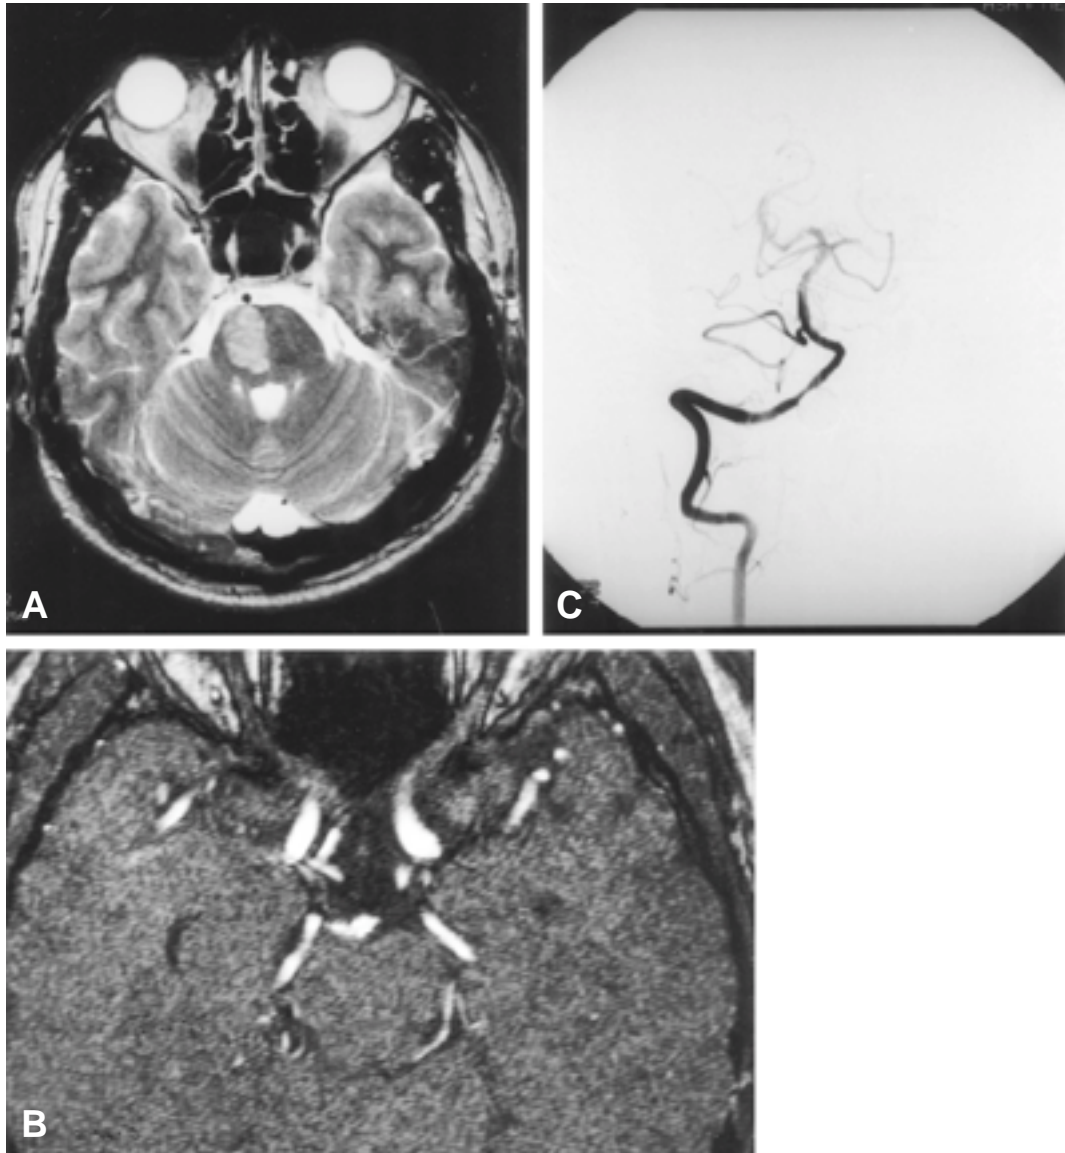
(A) Brain MRI (T2-weighted) shows acute infarction of the right pons. (B) Brain MRI (source image) shows a transverse intimal flap in the basilar artery. (C) Vertebral angiogram (anterior-posterior view) demonstrates segmental luminal narrowing in the basilar artery and multiple emboli in both posterior cerebral arteries.
